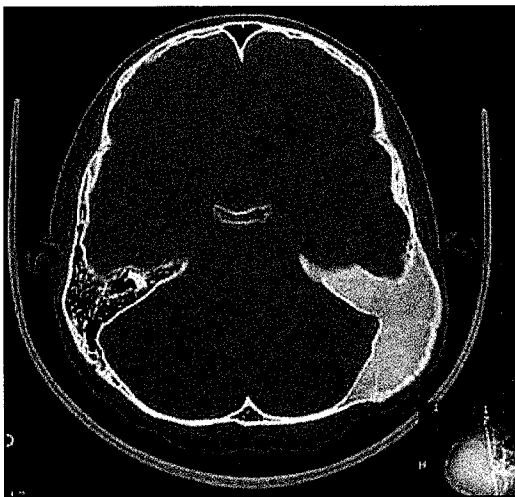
CT showing ground glass appearance of the left temporal bone, extending to the petrous apex. The right temporal bone appears well pneumatized.
